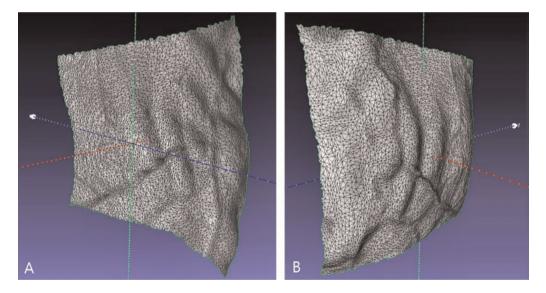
An example of the 3D mesh model (A — positive, B — negative) of the endocranial surface (parietal bone) recreated from CT scans of the human skull. Concave grooves reflect the course of the dura matter vessels (A); convex folds correspond to the arrangement of the cerebral gyri (B).
